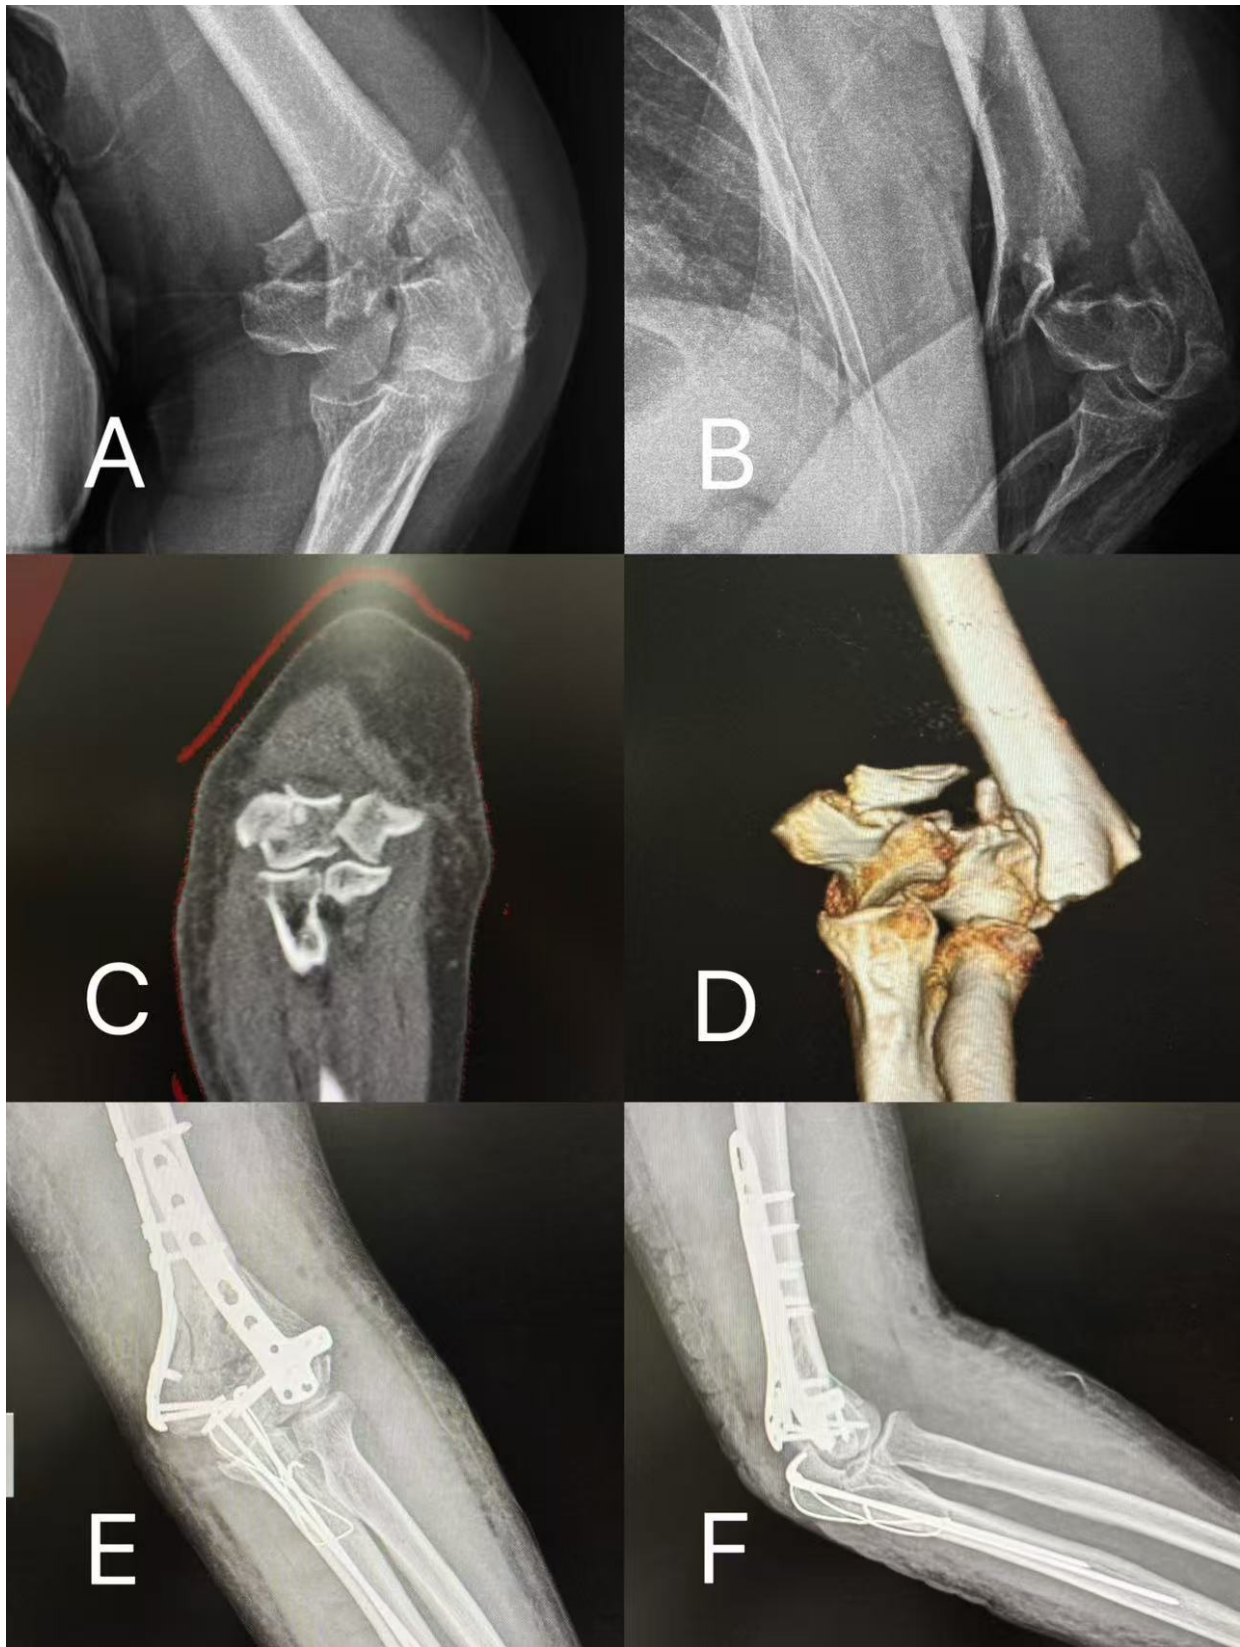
Preoperative and postoperative imaging of an AO type C3 distal humeral fracture with an incomplete articular surface of the trochlear fragment treated via olecranon osteotomy approach with vertical double-plate internal fixation. (A,B) Preoperative anteroposterior and lateral X-rays of the left elbow joint. (C,D) Preoperative CT coronal view and 3D reconstruction images of the left elbow joint. (E,F) Postoperative anteroposterior and lateral X-rays of the left elbow joint.
